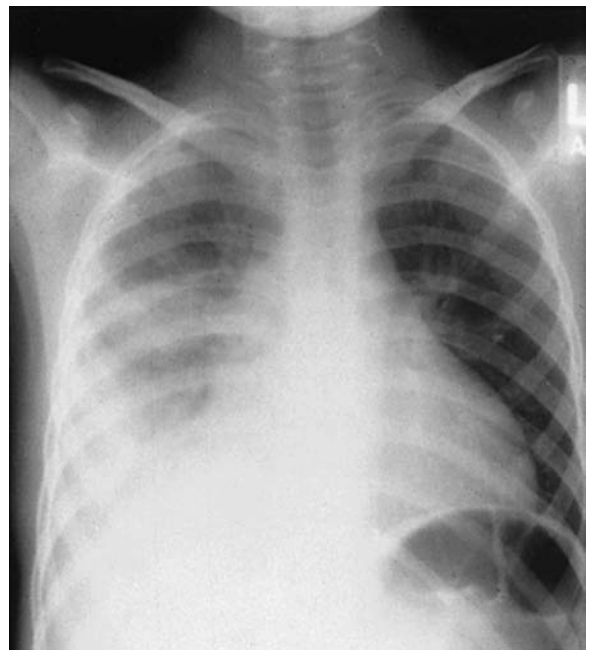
Radiograph showing lobar consolidation and pleural effusion in a child with bacterial pneumonia.
